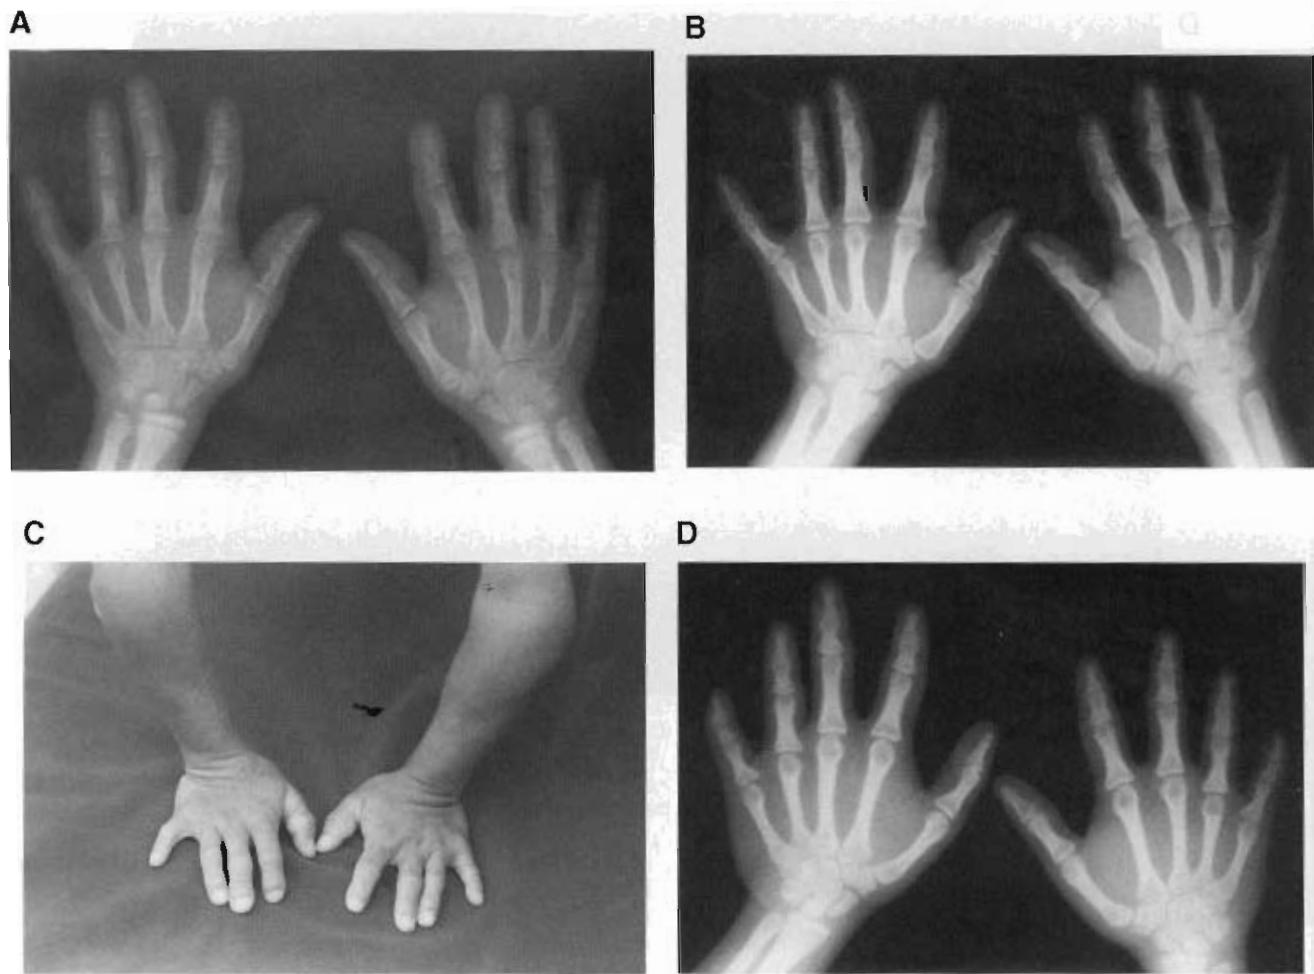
A: Hand radiograph of patient 1 at age 14. Note ivory and cone-shaped epiphyses. Trapezium and scaphoid have angular appearance. B: Hand radiograph of patient 1 at age 18. Absence of ivory and cone-shaped epiphyses. Brachymesophalangy and short distal phalanx of the right second finger. Metacarpals 4 and 5 are slender. C: Patient 1. Brachydactyly and bent elbows. D: Patient 2. Hand radiograph at age 16. Brachymesophalangy is noted. Trapezium and scaphoid have angular appearance. Metacarpals 4 and 5 are slender.
